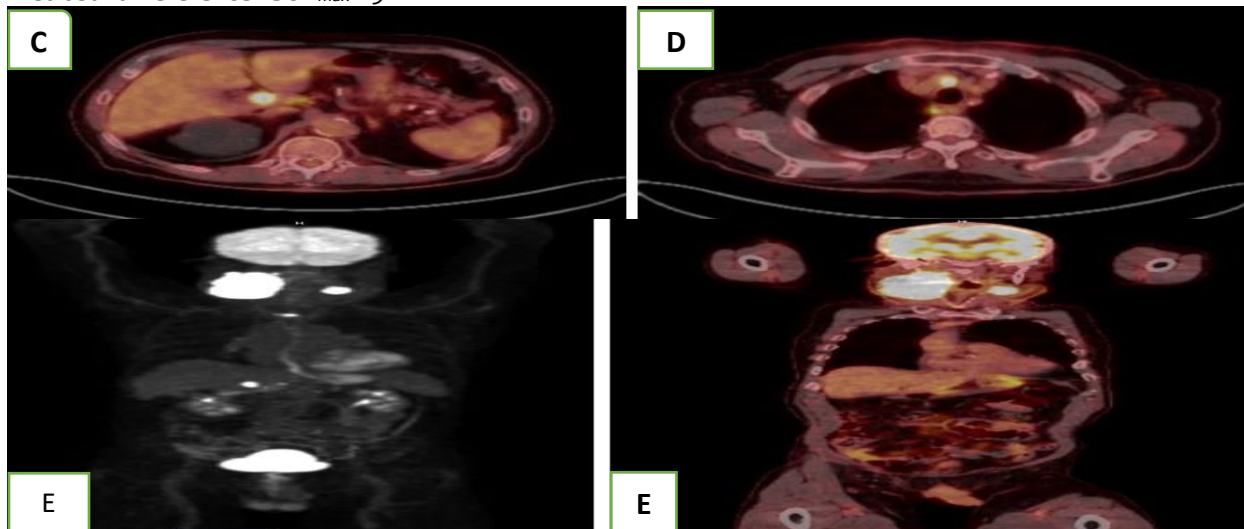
C, D & E are axial and coronal cuts of PET/CT scan after target therapy. Image C, D show newly developed porta hepatis lymph node measures 3 x 3 cm, SUV_{max} 19.9 and a pretracheal lymph node measures 3 x 2 cm, SUV_{max} 14.8, respectively. Image E is coronal cut showing still seen bilateral cervical FDG avid lymph nodes (SUV_{max} became 36.1 on the right side and 29 on the left side, in comparison to previous 32.8 and 26.6, respectively, with the newly developed porta hepatis and pretracheal lymph nodes (progressive metabolic course), DS 5
